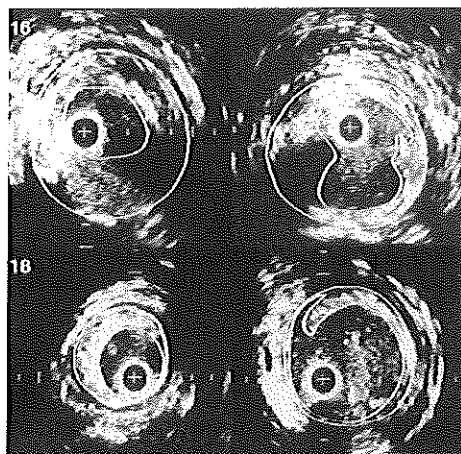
Corresponding intravascular sonography cross sections obtained at the smallest free lumen area (FLA) of the common iliac artery (level, 16 cm) and external iliac artery (level, 18 cm) before (left panel) and after (right panel) percutaneous transluminal angioplasty (PTA) in a 57 year old man. Cross sections were contour-traced off-line, facilitating recognition of the FLA (inner contour; solid arrow) and media-bounded area (outer contour; open arrow). After PTA, dissection was seen at both levels. + = catheter; calibration = 1 mm.
